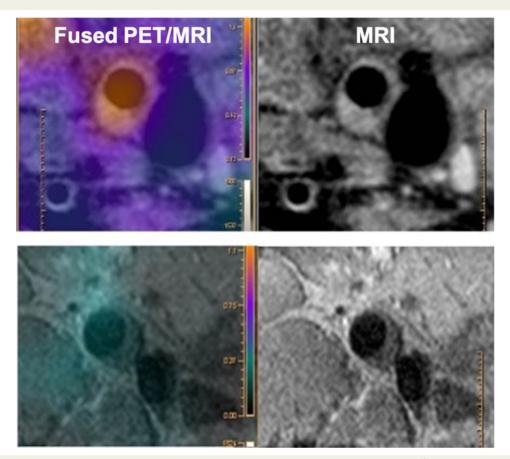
Positron emission tomography/magnetic resonance imaging analysis of the atherosclerotic plaque ¹⁸F-fluorodeoxyglucose uptake. The upper row shows a carotid atherosclerotic plaque with ¹⁸F-fluorodeoxyglucose uptake. The lower row shows a femoral atherosclerotic plaque without ¹⁸F-fluorodeoxyglucose uptake.
